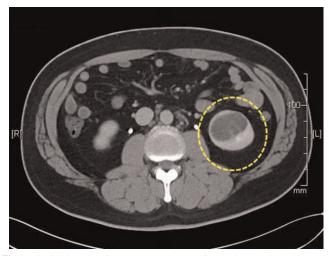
Axial magnetic resonance image of complex cystic renal mass (Bosniak classification III) in the interpolar area of the left kidney. The yellow circle indicates the region of interest.
